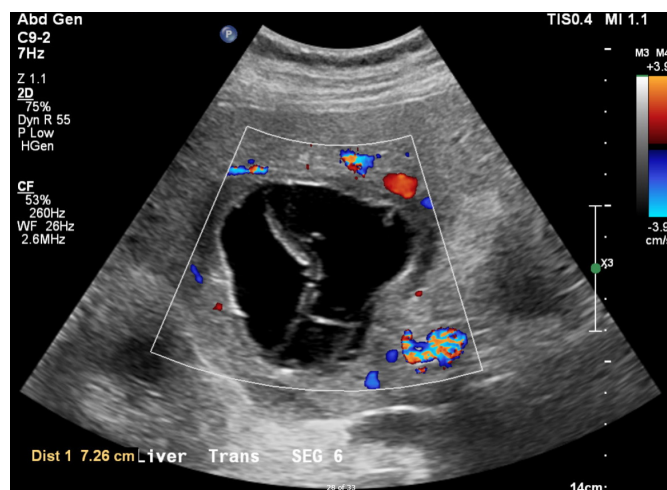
Selected transverse hepatic colour Doppler ultrasound image demonstrating no intracystic vascularity.
